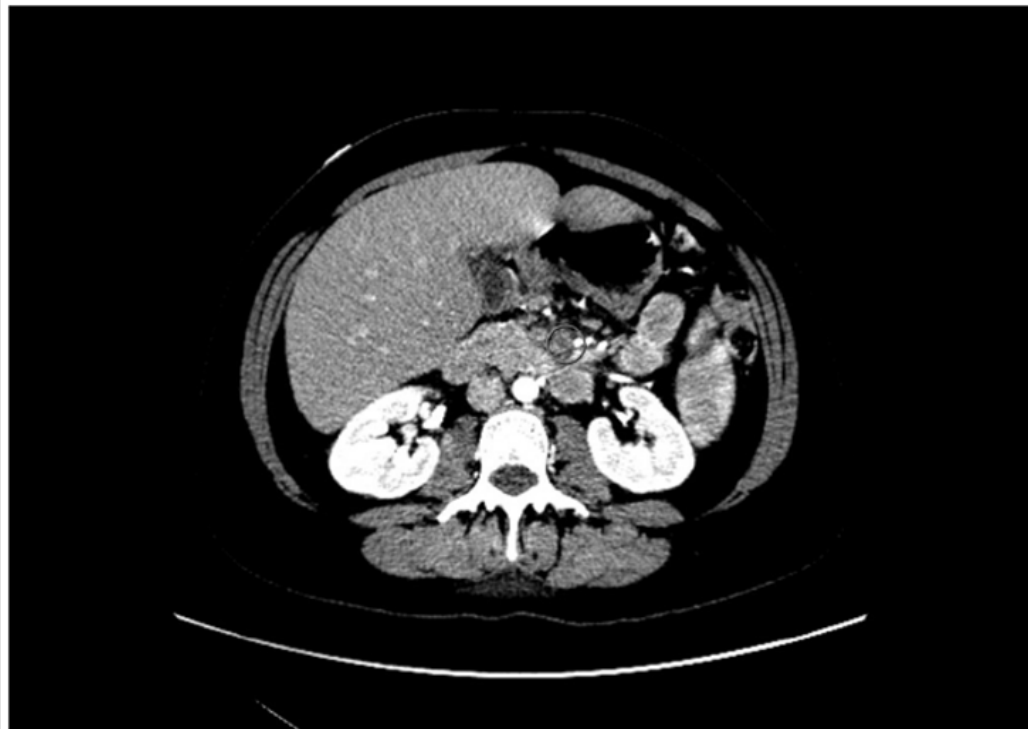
CT abdomen/pelvis obtained on admission showing concerns for superior mesenteric artery rupture and possible splenic infarct.
